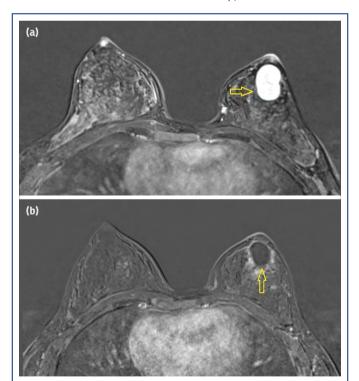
(a) A 27 mm, well-contoured lesion, which exhibited diffuse contrast enhancement in the left breast in contrast-enhanced magnetic resonance imaging (MRI) before microwave ablation (MWA), (b) The size of the lesion in the left breast was measured as 17 mm in contrast-enhanced MRI of the patient after MWA, and contrast-enhancement was not observed in the lesion secondary to the procedure
